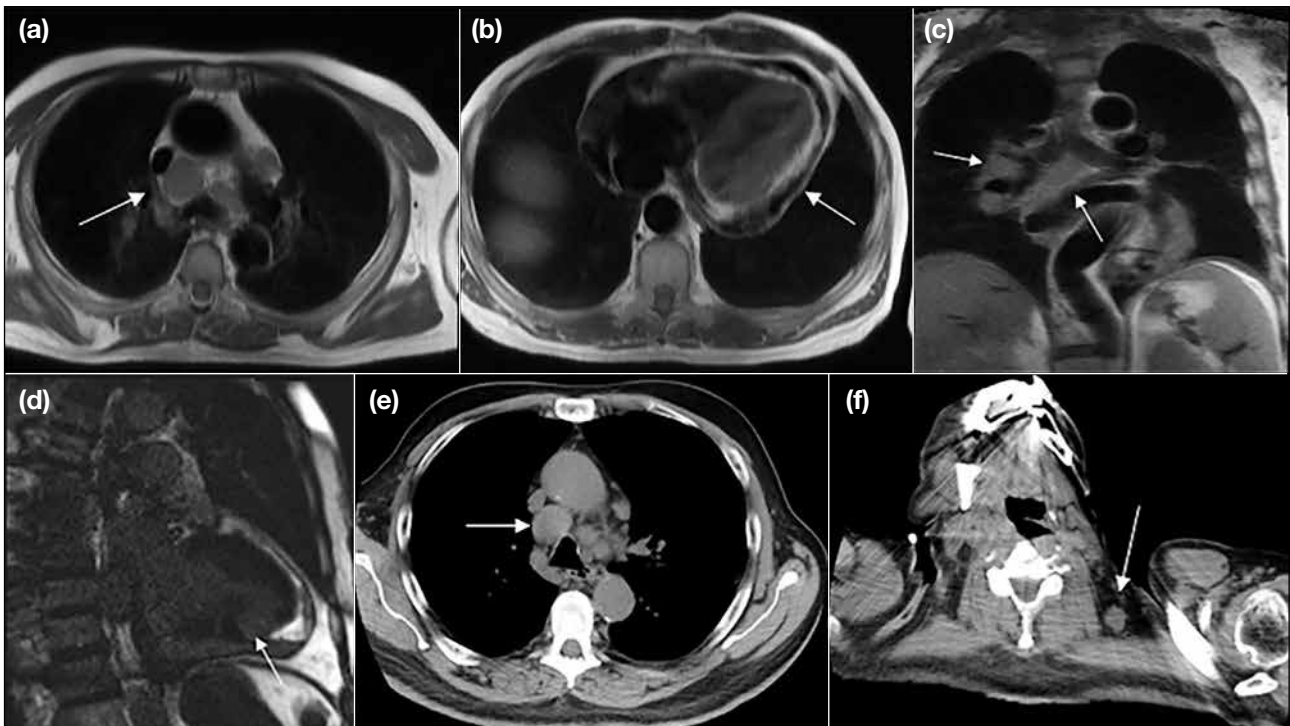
A 61-year-old male presented with dysarthria and facial weakness, pericardial effusion, and tamponade. (a) Axial black-blood image showing significant mediastinal lymphadenopathy (arrow). (b) Axial black-blood image showing pericardial thickening and collection (arrow). (c) Coronal black-blood image showing subcarinal and right hilar lymphadenopathy (arrows). (d) Long-axis phase-sensitive inversion recovery image with abnormal inferior wall myocardial enhancement (arrow). (e and f) Axial computed tomography images confirm the pathological lymph nodes (arrows). The patient underwent an open biopsy that revealed pericardial mesothelioma.
